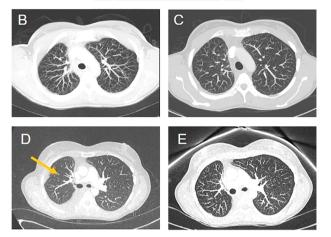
Thoracic computed tomography scans. (A): December 2016: diagnosis of locally advanced (stage IIIA) NSCLC. (B): September 2017: multiple millimeter-sized lung metastases. (C): November 2017: complete resolution of the lung lesions. (D): May 2019: new secondary lesion in right lung (yellow arrow). (E): August 2019: complete disappearance of the lung metastases.
